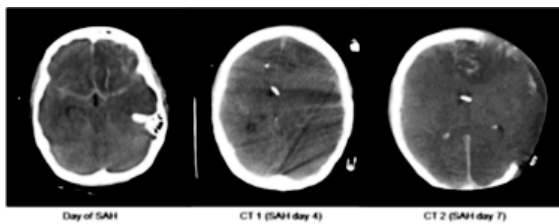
Example of MMM changes preceding hemicraniectomy in a subarachnoid hemorrhage patient (reference: Stuart et al. *Neurocrit Care* (2011) 15:146–150). Intracranial pressure (ICP), cerebral perfusion pressure (CPP), mean arterial pressure (MAP), lactate: pyruvate ratio (LPR), and brain tissue oxygen tension (PbtO₂) trends for post-bleed days (SAH days) 2–8. Infusion rates of norepinephrine and vasopressin are also displayed, as well as timing of head CT's. Before craniectomy, note the decrease in CPP and MAP despite increasing rates of norepinephrine and vasopressin, as well as the early rise in LPR >40, decrease in CPP <40 mm Hg, and late decrease in PbtO₂ <25 mm Hg. In the hours immediately preceding hemicraniectomy, the LPR was actually greater than the CPP. After craniectomy, ICP was maintained <25 mm Hg and CPP >60 mm Hg, and all pressors were weaned to off within hours. The PbtO₂ probe malfunctioned immediately post-surgery (Courtesy of N Badjatia, University of Maryland).
